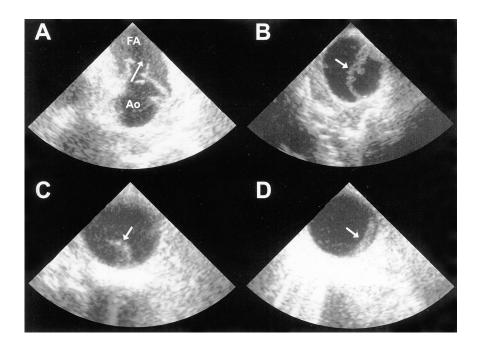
Transesophageal echographic aspect of main categories of traumatic aortic injury. (A) Traumatic aortic rupture (grade 3) with false aneurysm (FA) communicating (arrow) with the aortic lumen (Ao); (B) Traumatic aortic rupture (grade 2) with a large medial flap; (C) Intimal flap without hemomediastinum or modification in the aorta geometry (D) Intramural hematoma (arrow) with out haemomediastinum; (C) and (D) correspond to minor aortic injury (grade 1).
